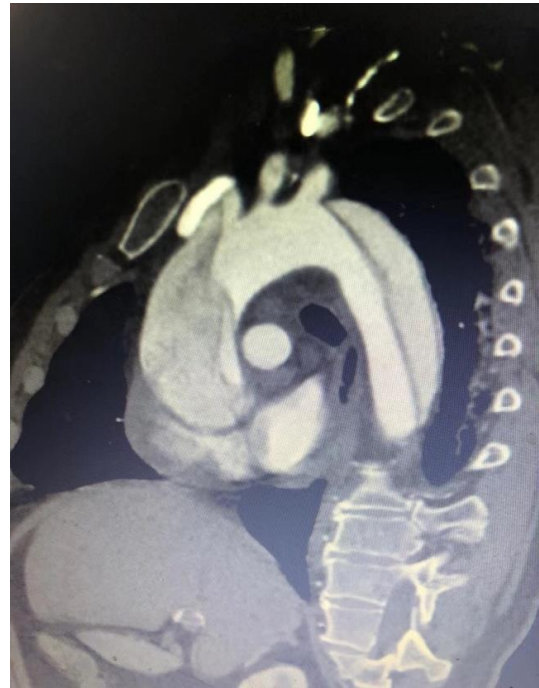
CTA of Type-A aortic dissection
